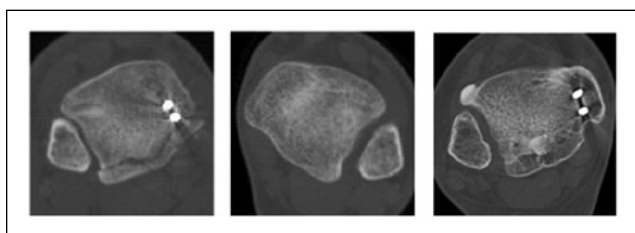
CT scans of a 22-year-old male with a Weber C ankle fracture with associated medial and posterior malleoli fractures treated with open reduction internal fixation including one 4.5 mm quadricortical syndesmosis screw. Immediate postoperative CT scan (left) shows overtightening of the syndesmosis with decreased anterior and posterior fibular-incisura distance compared to the contralateral ankle (middle). The postsyndesmosis screw removal CT (right) shows interval spontaneous reduction.
